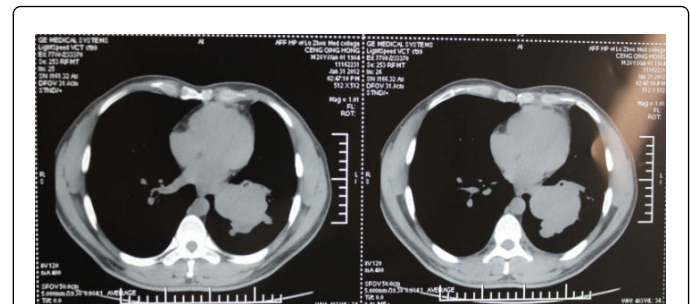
CT scanning: a 4 × 5 cm, well-defined giant mass in the left lower lobe.
